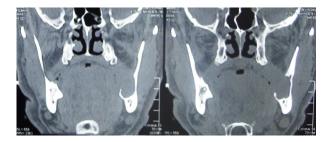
CT scan reveals cortical destruction and soft tissue extension.
